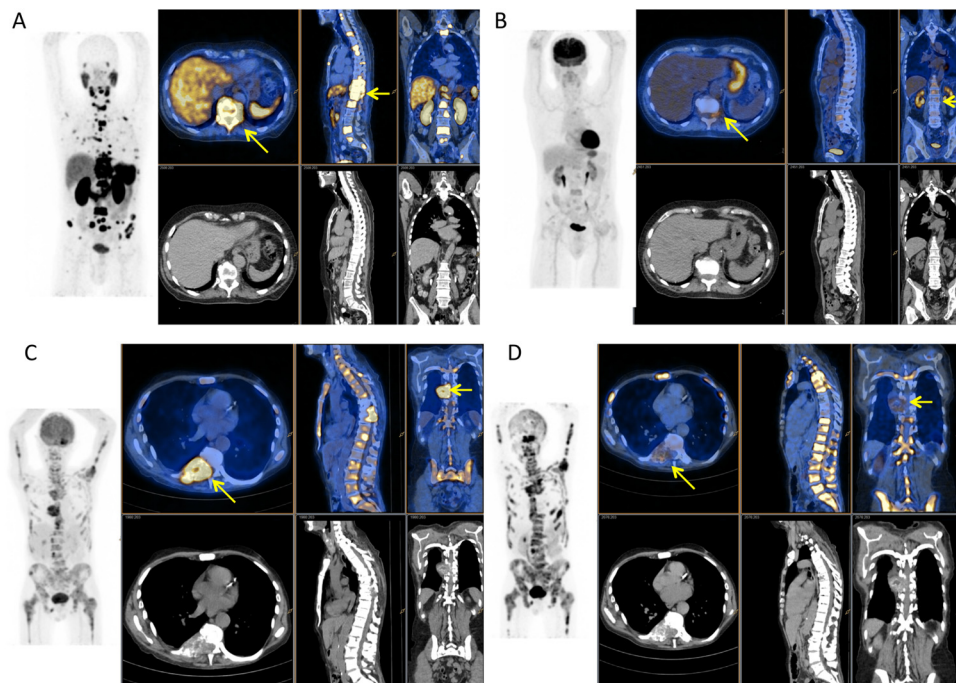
The patient was classified as a screen imaging pass (A) with multiple sites of PSMA-avid disease, (B) with no regions of PSMA SUV max < 10 at sites of measurable disease and no regions of FDG avidity in the absence of PSMA avidity. The patient was classified as an imaging screen failure (C) with a large mixed soft tissue/bone metastasis in the mid thoracic spine that is highly FDG avid, (D) with no significant PSMA avidity. This metastasis was very symptomatic and at a site of prior radiotherapy. FDG = ^{18}F -fluorodeoxyglucose; PSMA = prostate-specific membrane antigen; SUV = standardised uptake value.
